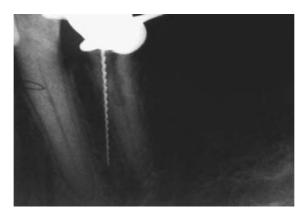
Radiograph showing the H-File penetrating the perforation.
